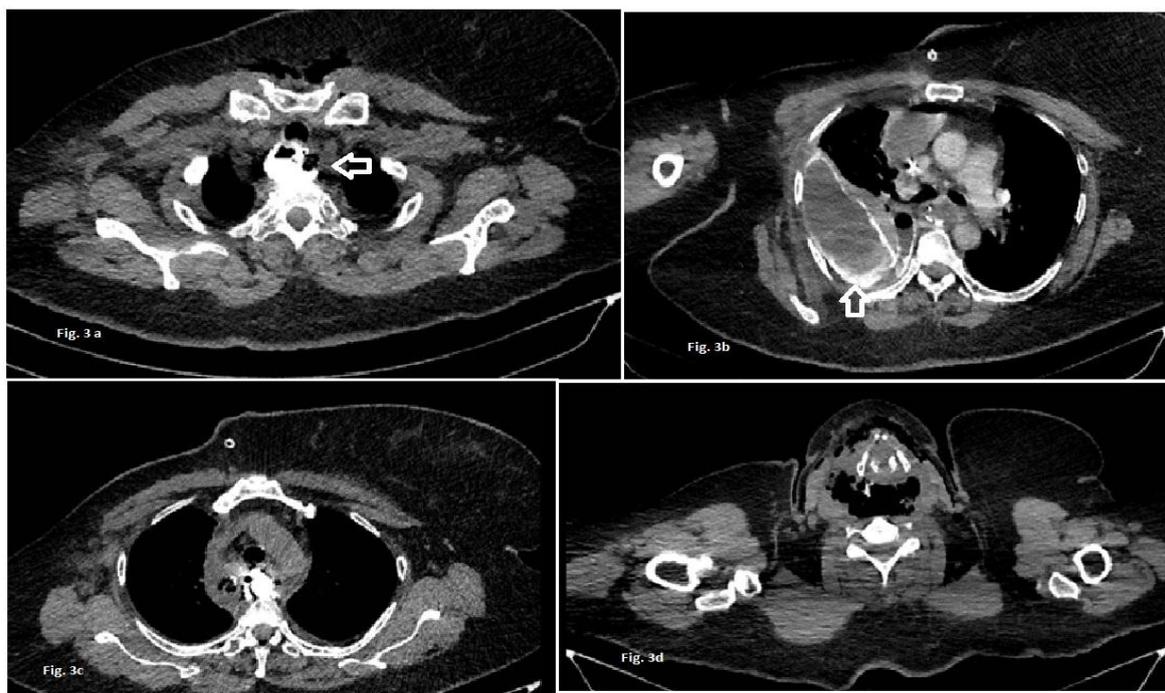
(a) Axial CT image showing site [white arrow] of esophageal rupture at D1 vertebral body level. (b) Axial CT images showing spillage of oral contrast in mediastinum and right pleural cavity through site of esophageal leak. (c) Mild paraesophageal collection / thickening is seen. (d) Axial CT image showing pneumo-mediastinum extending superiorly into neck (as was seen on lateral cervical radiograph, Fig. 2b).
